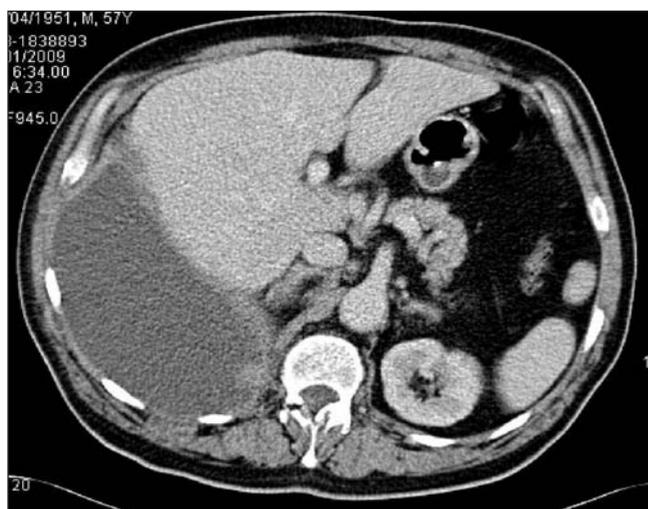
CT: thickening of right pleura.
